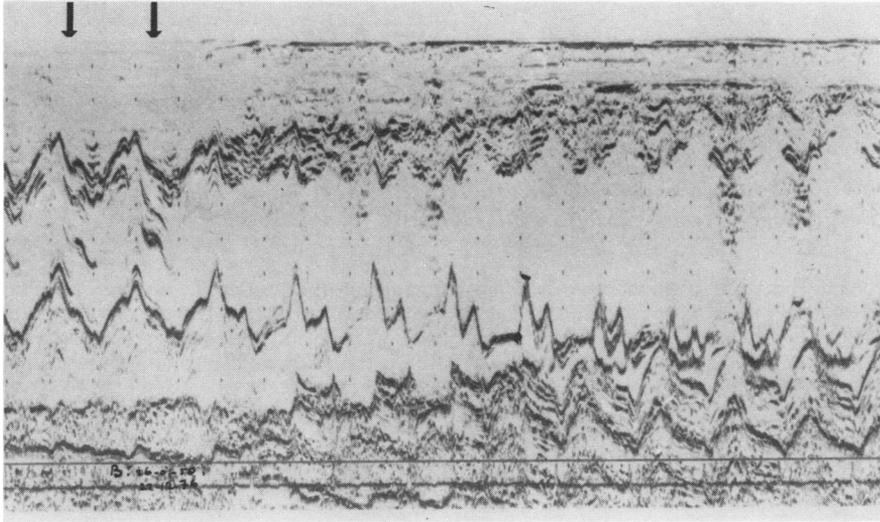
Echocardiogram showing multiple closing lines in the aortic valve opening (arrows).
